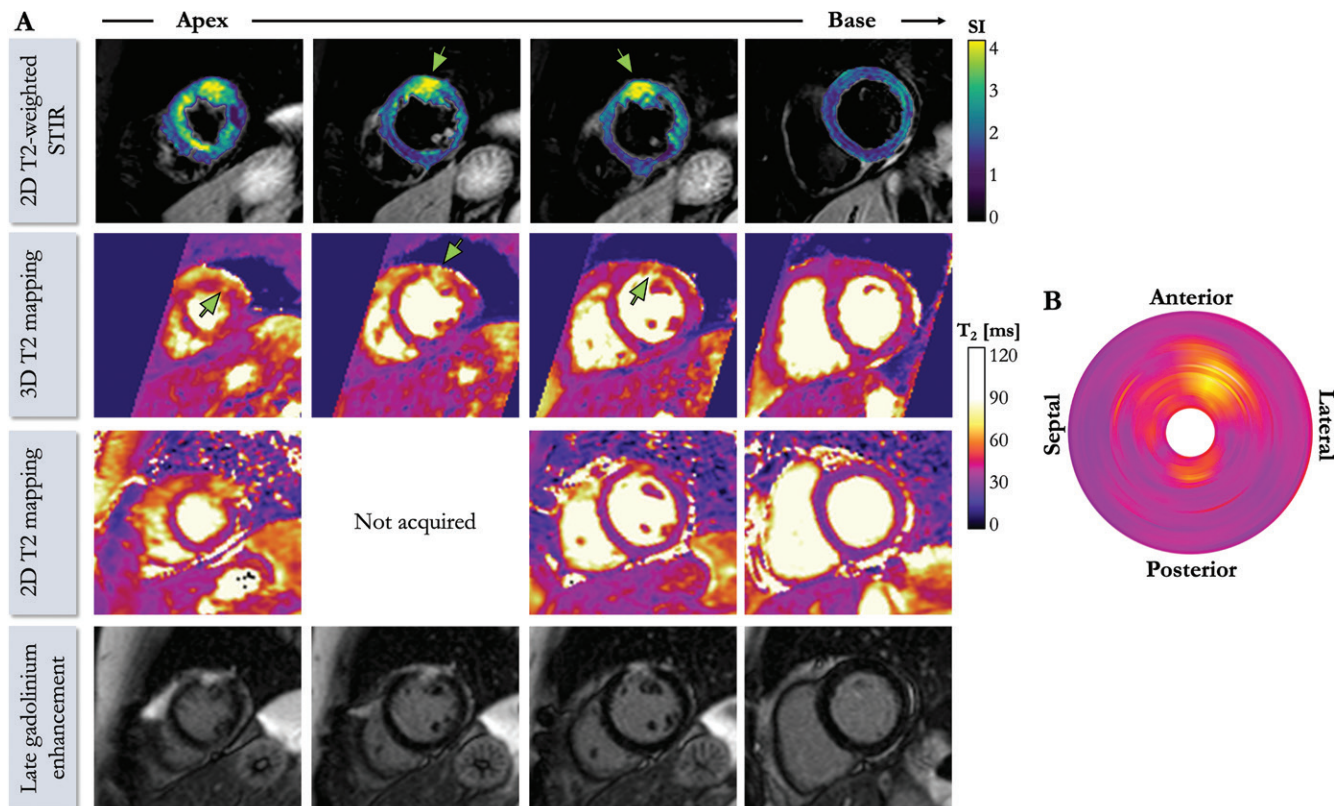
A, Cardiac MRI scans in 61-year-old female participant (cohort 2) with embolic myocardial infarction admitted to hospital with chest pain and minor coronary disease at x-ray angiography show focal transmurality increased myocardial signal intensity (SI) in midanterolateral wall on T2-weighted short inversion time inversion recovery (STIR) images. Further distinct area of focal transmurality enhancement is seen in apex. Subendocardial late gadolinium enhancement can be observed in midanterior and/or anterolateral wall, which toward apex becomes near transmurality. 2D = two-dimensional, 3D = three-dimensional. B, Half of tissue injury was not detected with conventional three-slice 2D T2 mapping, whereas 3D T2 map reveals larger extent of myocardial injury (arrows), as shown on this bull's eye plot. Acquisition of 3D whole-heart T2 map took 5 minutes 29 seconds.
